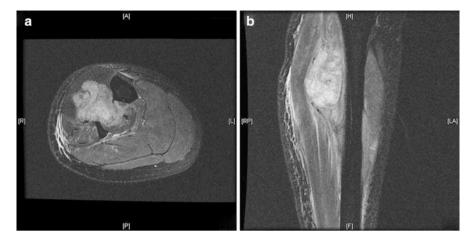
T2 contrast-enhanced fat-saturated MRI images of a primary alveolar soft part sarcoma of the calf. Tumor extends through the interosseous membrane
